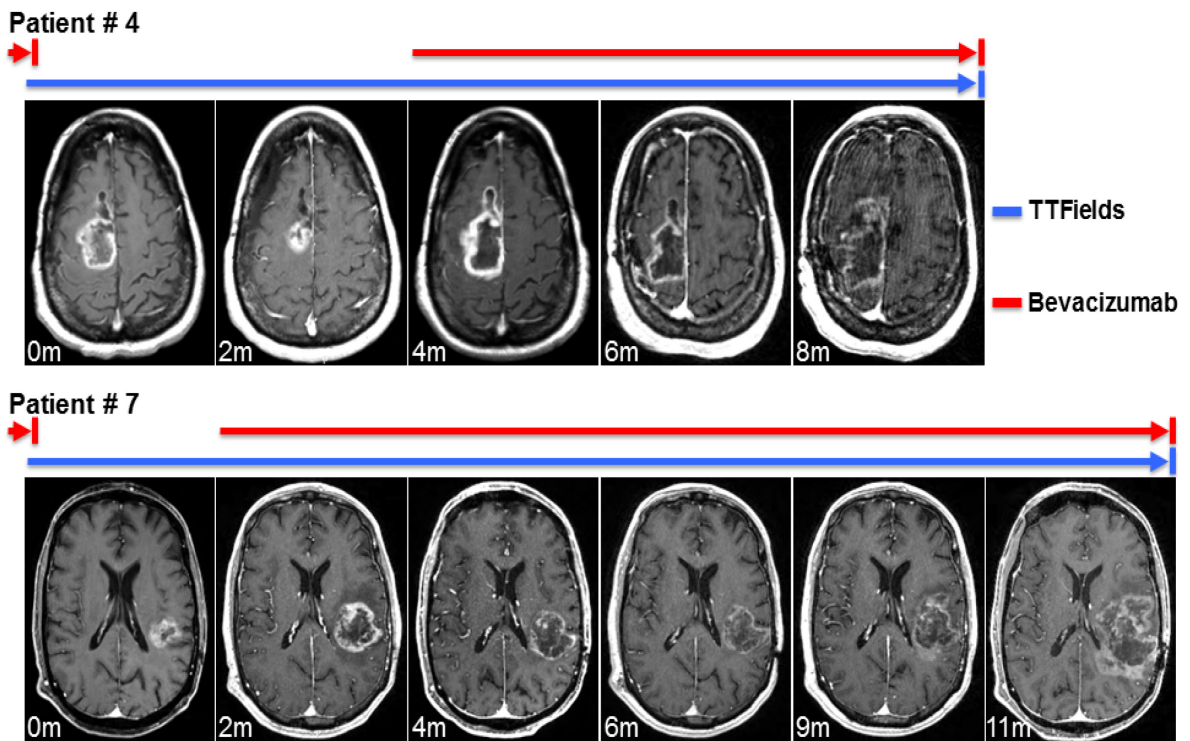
Radiographic appearance of bevacizumab-refractory GBM treated with TTFields and subsequently re-challenged with bevacizumab. Representative pictures of serial gadolinium contrast-enhanced brain MRI scans of Patients # 4 and # 7 are shown. Colored bars denote time line of TTFields and bevacizumab re-challenge in months, starting from the first documented radiographic diagnosis of bevacizumab-refractory GBM per RANO criteria. Patient # 4 demonstrated an initial response to TTFields at 2 months but progressed radiographically at 4 months. Upon re-challenge with bevacizumab, this patient’s GBM demonstrated a radiographic response again. Patient # 7 did not have a radiographic response to TTFields in the first 2 months. However, this patient had a durable radiographic response to bevacizumab re-challenge while continuing on with TTFields.
